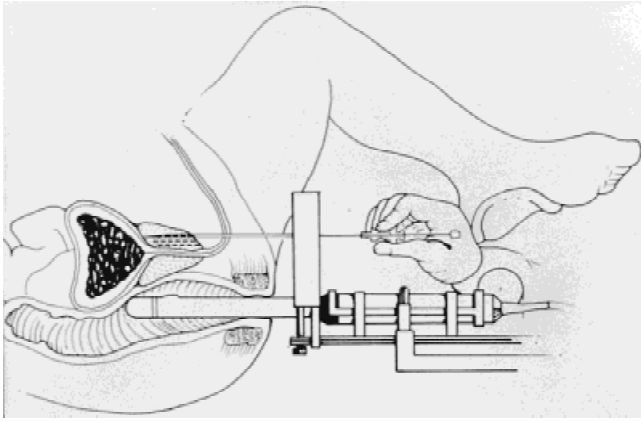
Modern closed transperineal ultrasound-guided seed implantation technique.
